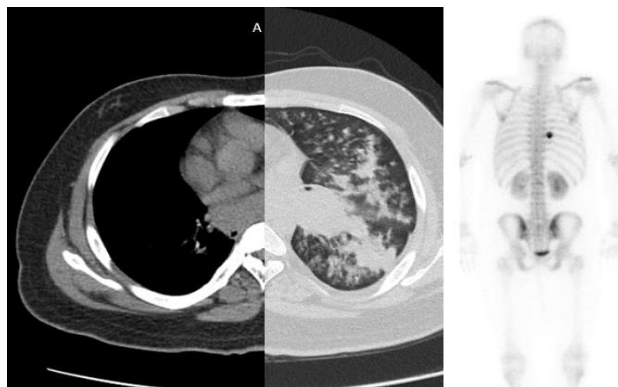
CT chest mediastinal and pulmonary window showing hilar and mediastinal lymphadenopathy and bone scan showing left 8th rib uptake.
